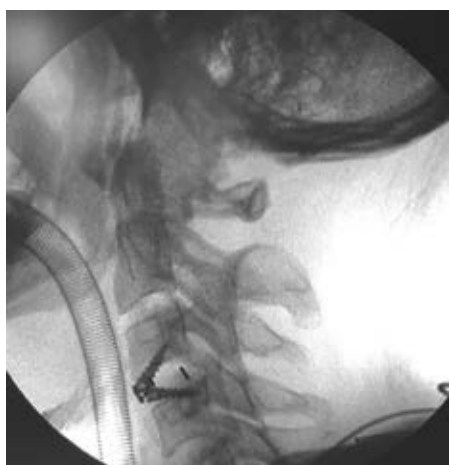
Trans surgical lateral X-ray shows the placement of cervical blockade cage C3-C4.
